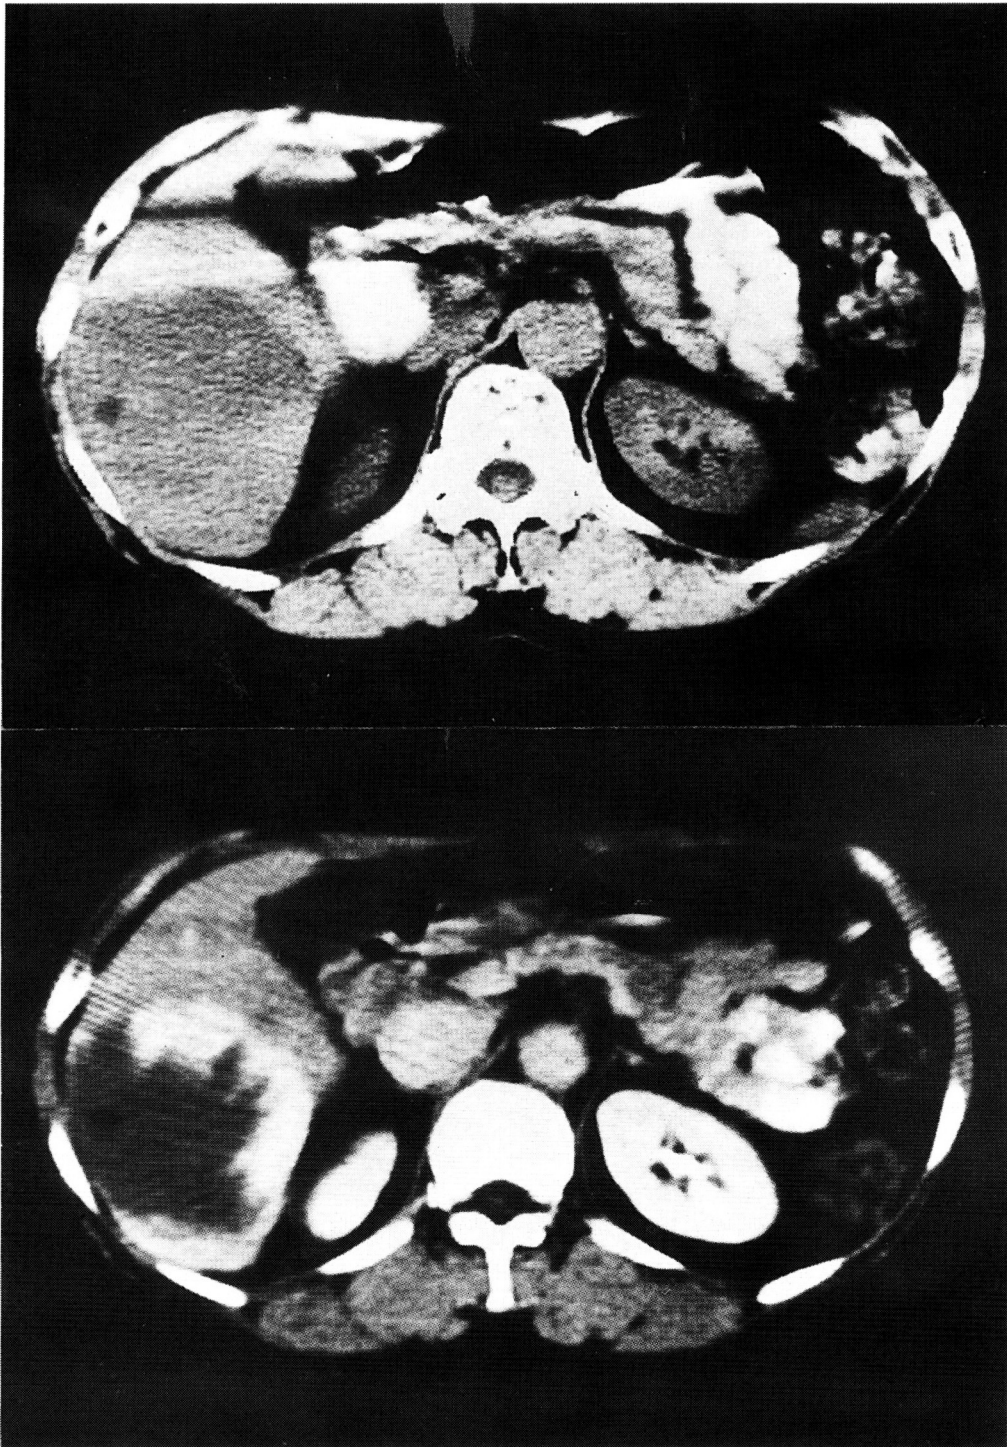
Computed tomography. Above, precontrast scan ; below, postcontrast scan. A large, homogeneous round lesion with low density is seen in the right lobe. The border between the main tumor and hepatic parenchyma is smooth(above). On postcontrast scan, irregular enhancement occurs in the periphery of the lesion with higher density than that of the hepatic parenchyma(below).
